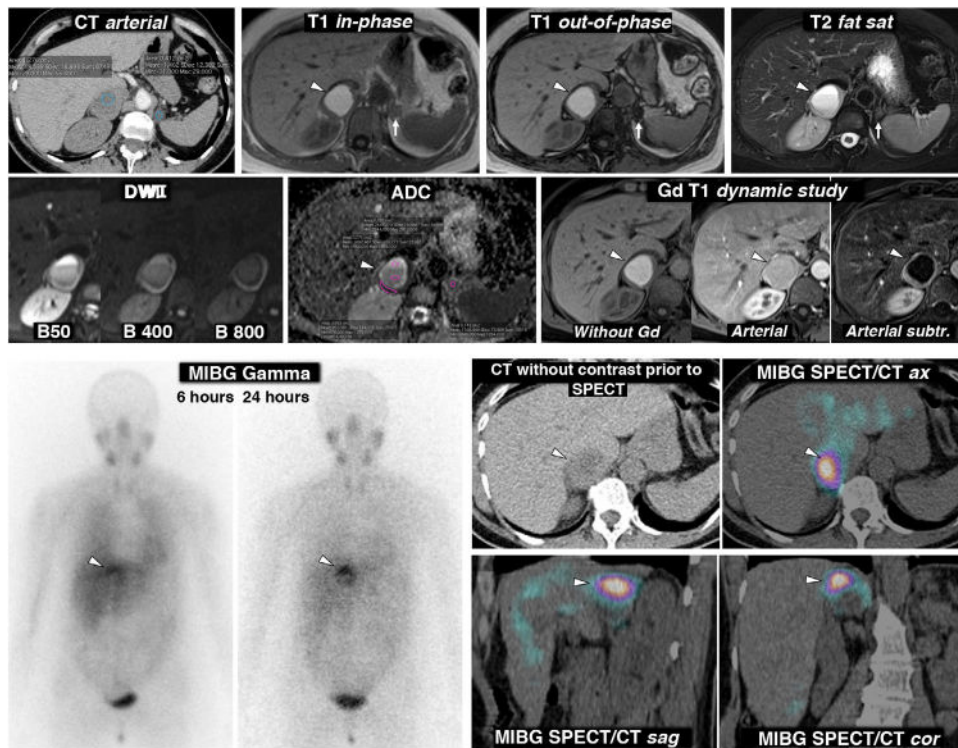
Pheochromocytoma as an almost purely haemorrhagic mass demonstrated by Nuclear Medicine. 58-year-old female. Went to the Accident and Emergency Department with headache and palpitations. Top: CT and MRI. Two adrenal nodules (elliptical ROI on CT), a larger right one, with mean attenuation values somewhat lower than 20 HU, nonspecific, and a smaller left one of -1.4 HU, characterised as a lipid-rich adenoma. The MRI shows that the right lesion (arrowheads) is an almost purely haemorrhagic lesion, with a high signal on T1, without a drop in signal out-of-phase in the interior or in its periphery. The left adrenal adenoma (arrows) does lose signal intensely out-of-phase (a montage of images has been made to show the centre of the two lesions in the same image). The right adrenal lesion shows a high signal on T2, with two fluid levels, which can also be seen in the diffusion-weighted sequence and in the ADC map, with progressively greater restriction of diffusion towards gravitational areas. In the wall of this lesion, the mean ADC values are $0.95 \times 10^{-3} \text{ mm}^2/\text{s}$. The adenoma has mean values of 1.17. As in other haemorrhagic lesions, recognition of parietal or nodular enhancements is facilitated by subtracting the baseline image. Bottom: scintigraphy and SPET/CT findings with ^{123}I MIBG. The scintigraphy study shows uptake by the right lesion (arrowheads), more evident in the study 24 h after the administration of the radiopharmaceutical. The SPET-CT study with the same radiopharmaceutical acquired at 6 h shows the uptake by the lesion more clearly, virtually confirming the diagnosis of pheochromocytoma. The left adenoma does not enhance.
